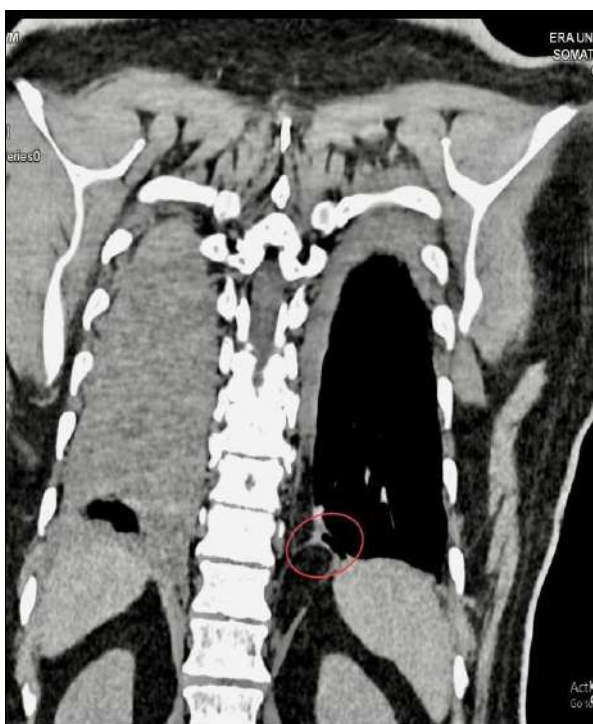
Coronal section of computed tomography image of patient with Bochdalek hernia with bilateral pleural effusion and eventration of right hemidiaphragm.
